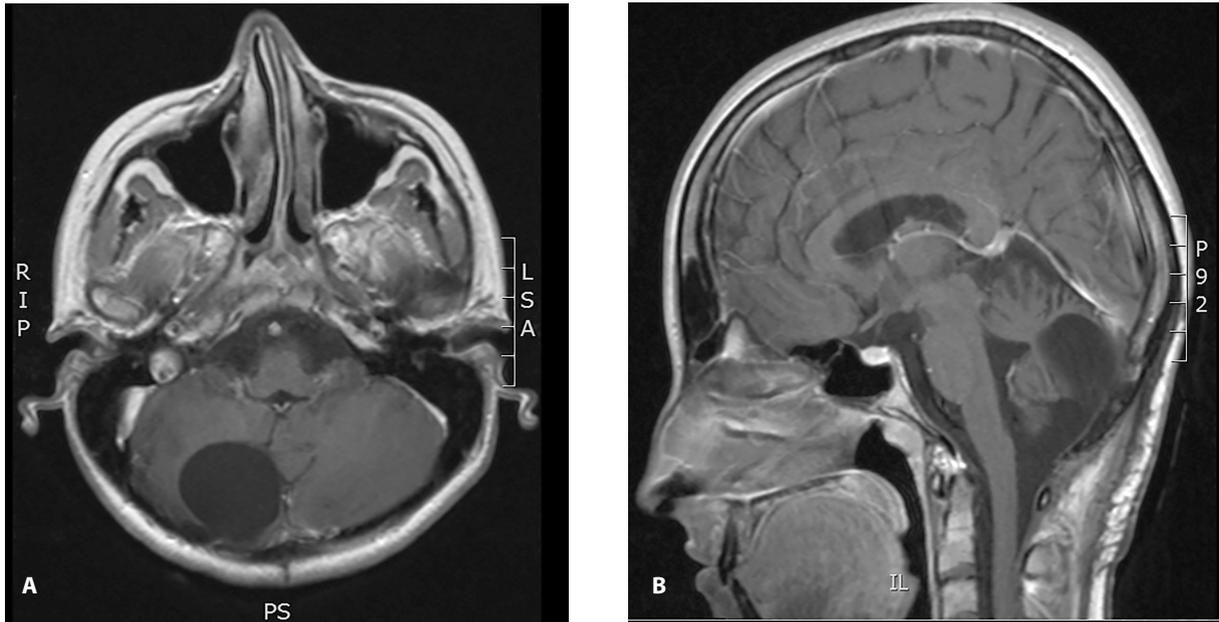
Postoperative axial (A) and sagittal (B) MRI without tumor remnant.
